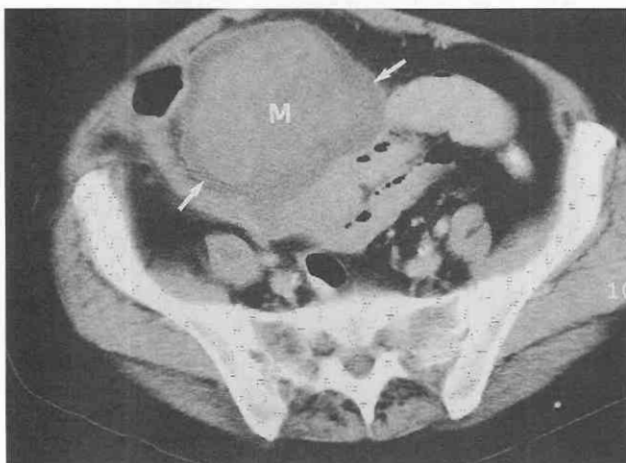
Solid adnexal mass. CT scan through the pelvis of a woman with acute abdominal pain and a lower abdominal solid mass (M). This image shows a rim of fluid (arrows) and a central solid element with lesser enhancement than muscle. At surgery, an infarcted pedunculated uterine leiomyoma was discovered.
